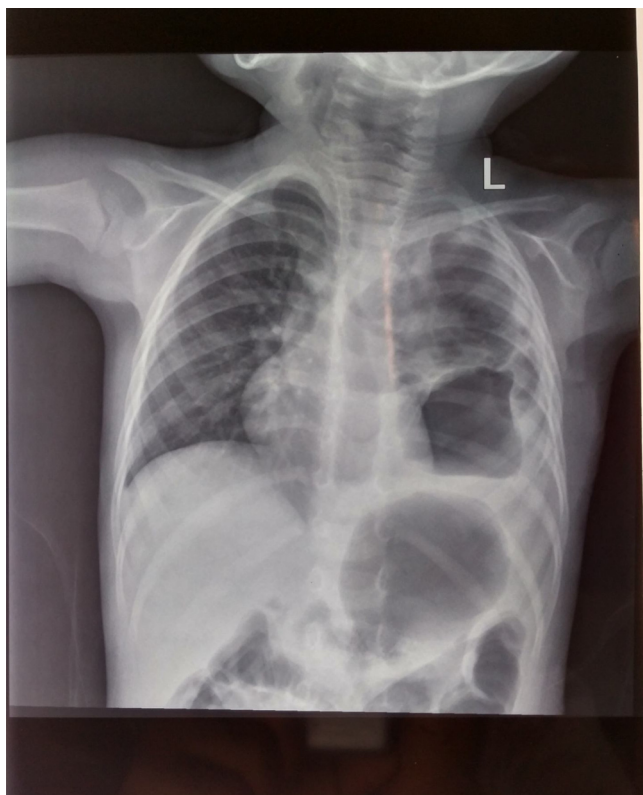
Post-operative chest X-ray showing the normalized shape of diaphragm with left lung expanded significantly and right lung fully and the mediastinum shifted back to its normal midline position.
